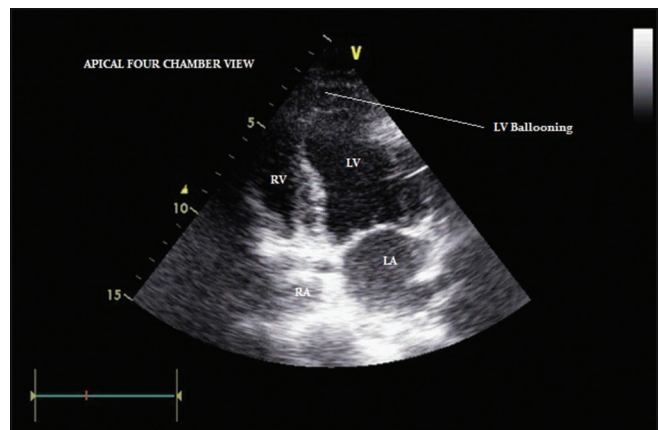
Apical four chamber view showing apical ballooning
